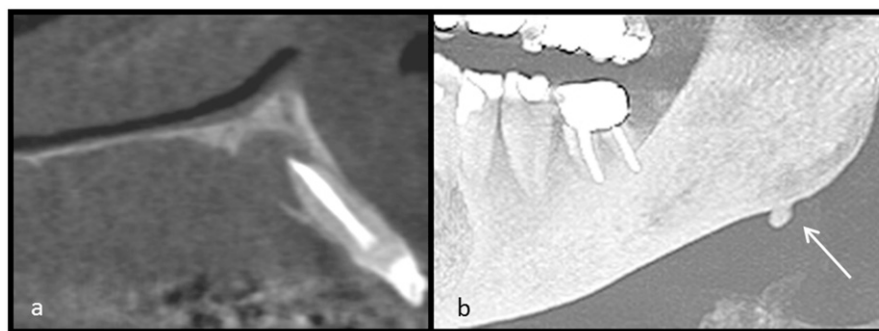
A periapical cyst in sagittal reformatting (a); arrow is indicating osteoma in the panoramic reformatting (b).
